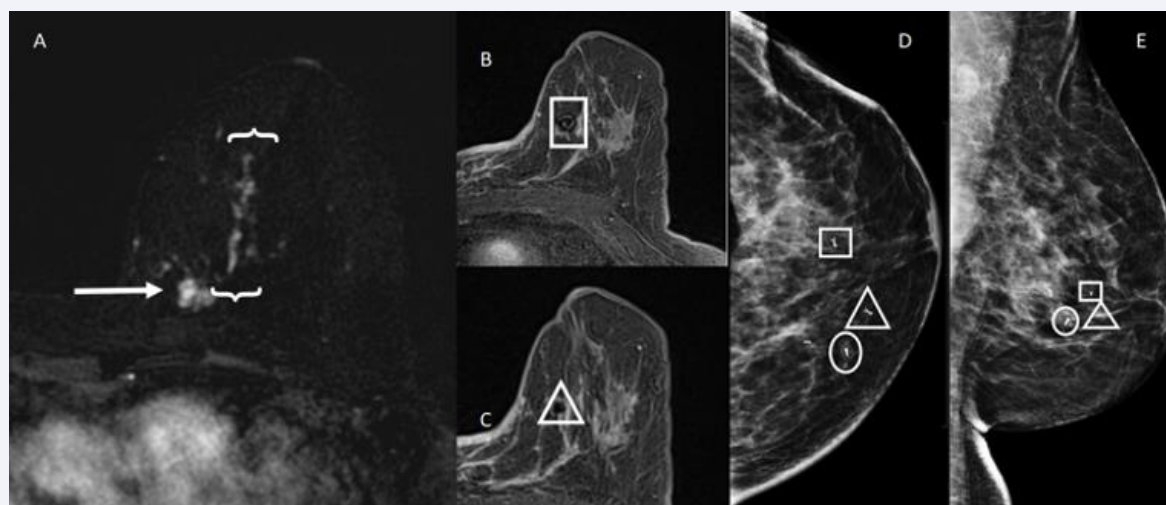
A: T1-weighted post-contrast subtraction MRI shows a lobular mass with irregular margins in the left breast upper inner quadrant (arrow). This finding is consistent with the index carcinoma. There is associated malignant appearing segmental, reticular non mass enhancement contiguous with the index mass extending anteriorly and laterally (brackets). B and C: Post-contrast MRI show clip marker placement in the anterior-superior (square) and lateral (triangle) most extent of enhancement. D and E: Craniocaudal and lateral post-clip mammography shows the index tumour (circle) and two ribbon clip markers delineating the anterior (triangle and square) and lateral (square) most extent of disease. Final pathology showed invasive and in situ ductal carcinoma with negative margins.
